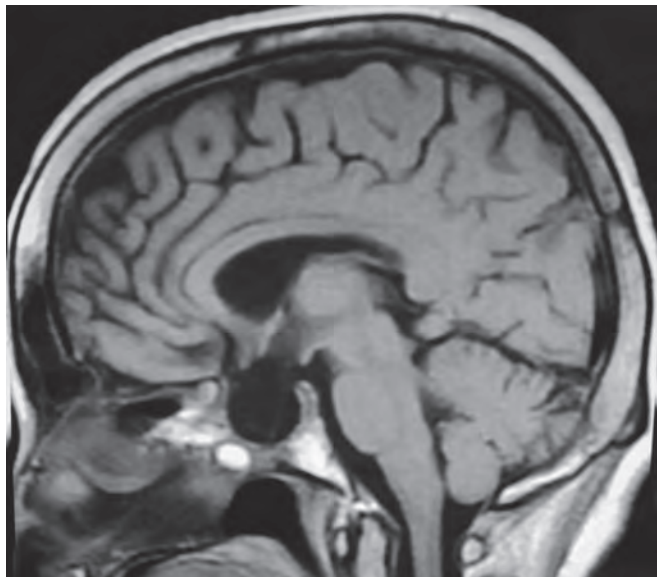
MRI sagittal of a patient with secondary empty sella showing evidence of trans-sphenoidal surgery with empty sella
